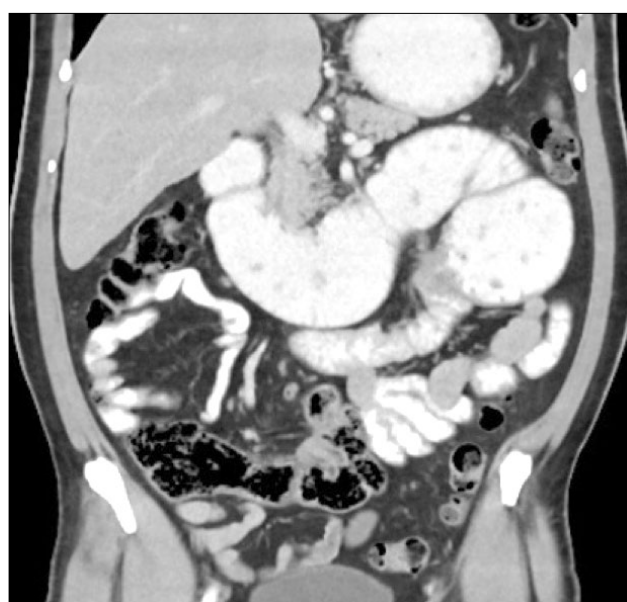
Emergency CT image showing a small bowel tumor.
